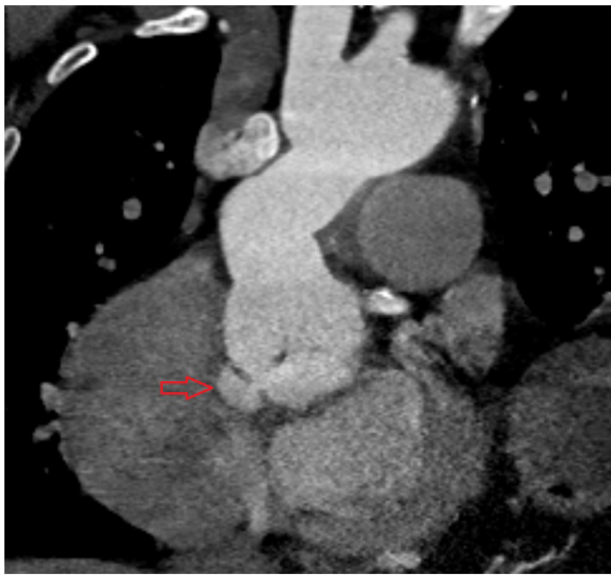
Cardiac computed tomography (CT) showing the same large (2 × 2.1 cm) perivalvular abscess in the aortomitral continuity (red arrow).
